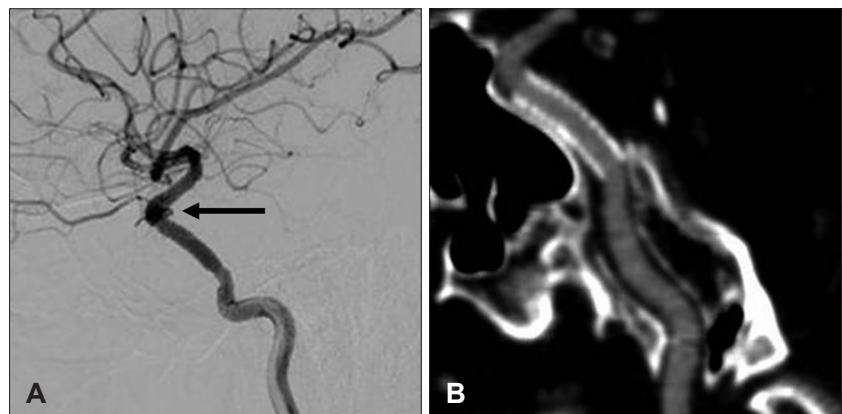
Lateral angiogram of left internal carotid artery after 8 months showing a complete obliteration of carotid cavernous fistula and pseudoaneurysm of the distal end of the stent (arrow) (A). Computed tomographic angiography 8 months later reveals normal patency of the internal carotid artery (B).
